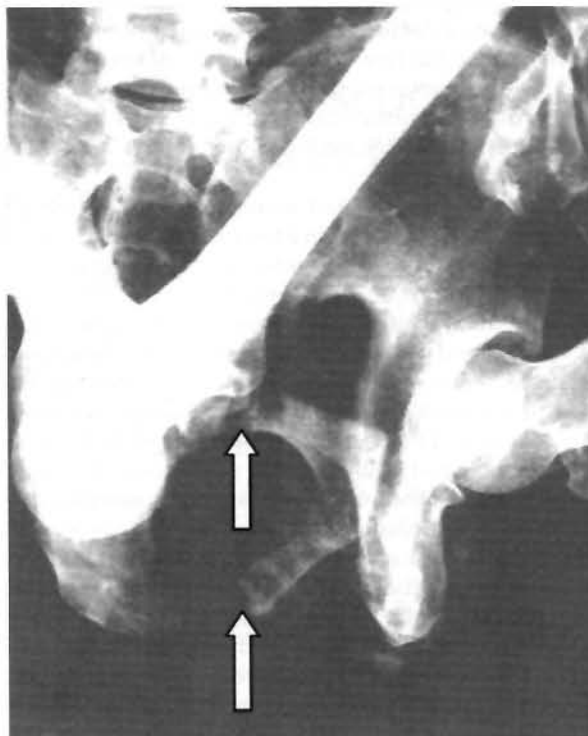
X-ray image of the pelvic fracture. Note the spaces between the medial and lateral parts of the rami.
